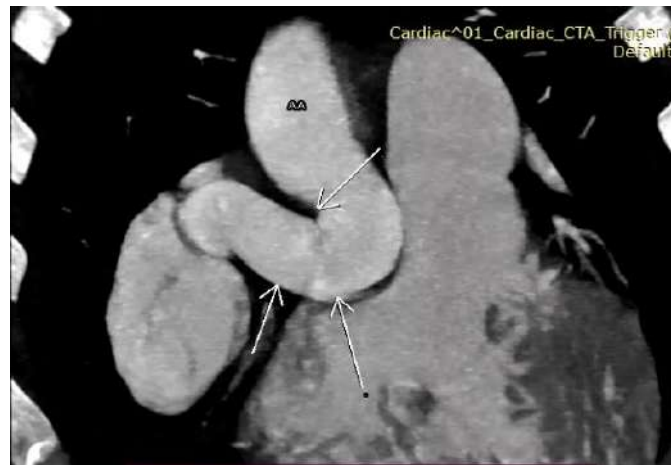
CT angiogram showed (5,6) dilated ascending aorta and aortic root with large fistula communicating right coronary sinus with right atrium, which was tortuous with 180 degree turn with constriction at different site.
